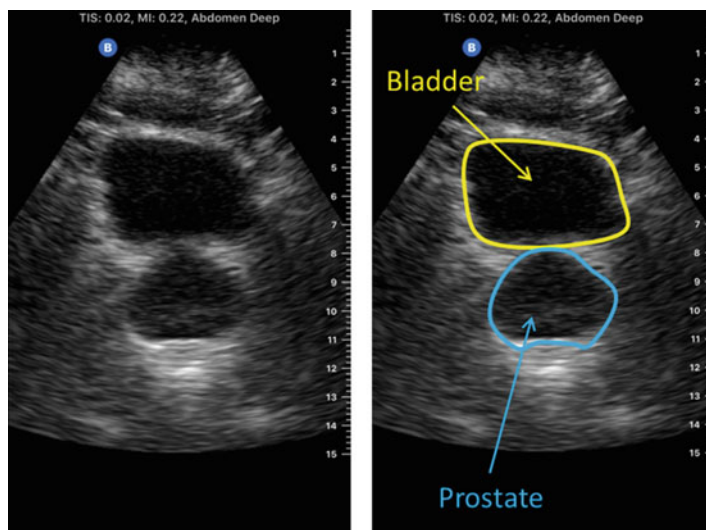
Ultrasound of prostate gland situated below the urinary bladder. The prostate gland adds enzymes and other secretions to the seminal fluid providing nourishment and energy for the sperm during transit to the female reproductive tract. Prostate function is supported by conversion of testosterone secreted from the testes into dihydrotestosterone (DHT), a more potent androgen
